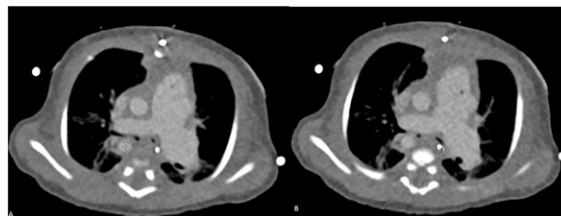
Computed tomographic chest imaging in a patient with Tetralogy of Fallot and absent pulmonary valve. (A) Severe compression of the right mainstem bronchus between the right pulmonary artery and descending right-sided thoracic aorta. (B) Severe compression of the left main bronchus between the left pulmonary arterial aneurysm and esophagus.
